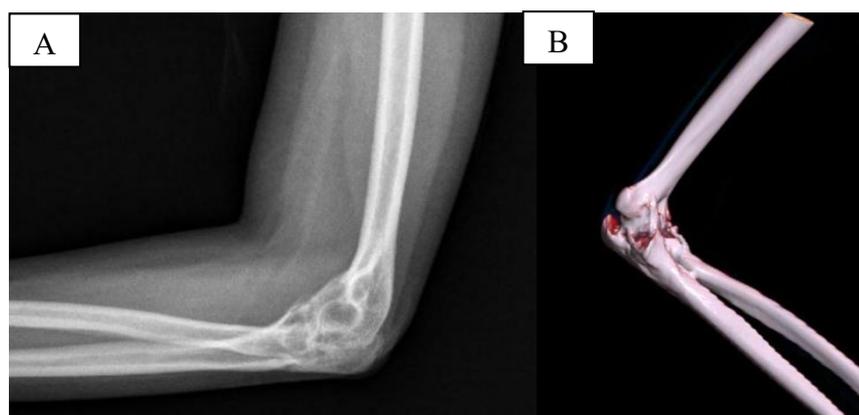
The radiological examination of X-ray (A) and 3D CT-scan (B) reconstruction of left elbow. (Source: internal documentation)
